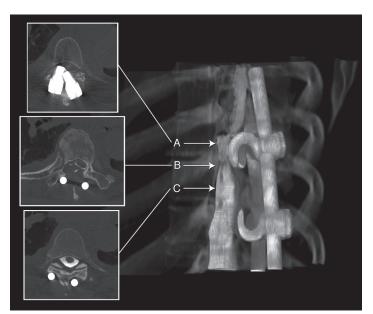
Two-dimensional computed tomography myelogram and corresponding 3D reconstruction of the injured spinal cord from the identical data set. Physical examination of the patient confirmed complaints with findings pathognomonic for Brown-Sequard type spinal cord compression or hemisection (A). Compression of the thecal sac is definitively demonstrated in high resolution (B). The normal thecal sac is also demonstrated (C).
